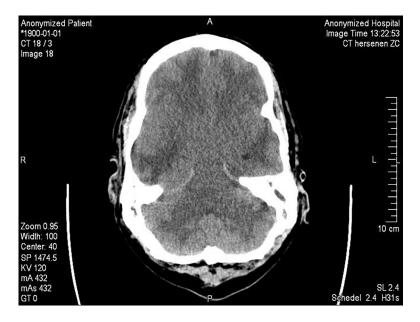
Transversal cerebral CT scan showing extensive vasogenic edema and herniation of temporal lobes toward the brain stem with obliteration of basal cerebral cisterns.
